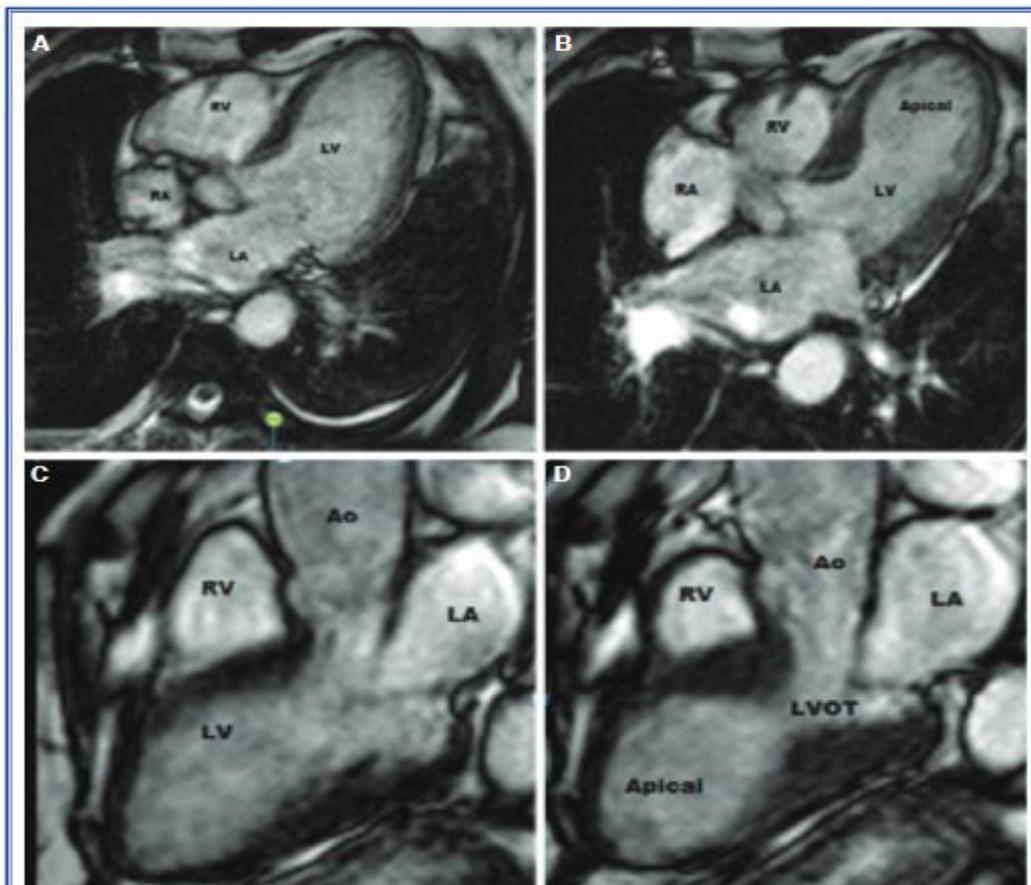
(A) On cardiac magnetic resonance images, left ventricular diastolic phase on horizontal axis, (B) left ventricular systolic phase, (C) left ventricular diastolic phase on sagittal axis and, (D) left ventricular systolic phase
